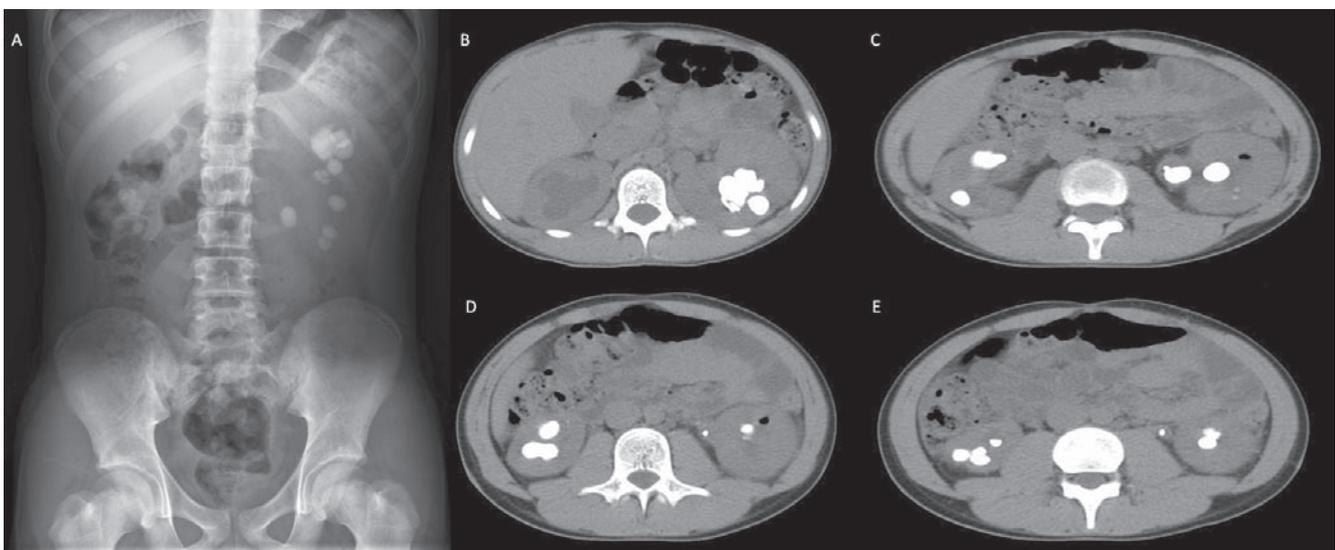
A (abdominal X-ray), at least 12 left radiopaque images projected onto the left renal silhouette and 4 right radiopaque images projected onto the right renal silhouette. These findings are compatible with stones. B, C, D and E (abdominal CT scan) images of multiple and bilateral stones, which were suspected in abdominal X-ray, with decrease in both kidney parenchymas.
